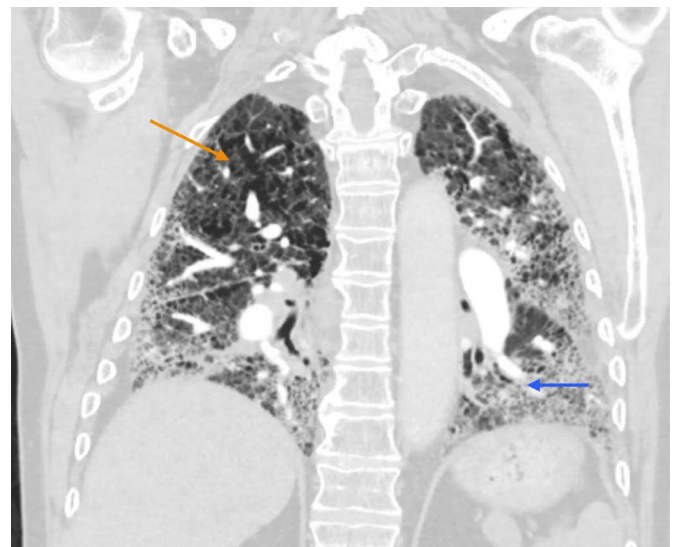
CT Chest with IV contrast, coronal view, lung window, demonstrating severe emphysema in the upper lobes (orange arrow) and severe honey combing in the lower lobe's indicative of fibrosis (blue arrow). This pattern is consistent with Combined Pulmonary fibrosis with emphysema.
